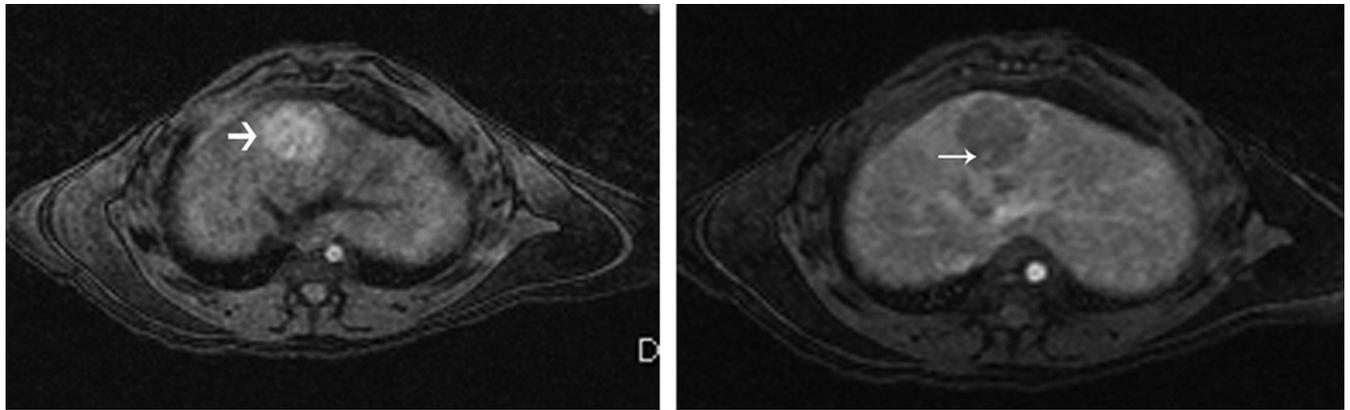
MR imaging appearance of treated HCC in a woodchuck model. (a) Precontrast T1-weighted image shows a spherical area of hyperintense signal at the site of ablation (arrow). (b) After intravenous gadolinium administration, the lesion shows minimal peripheral enhancement with subtle areas of nodularity (arrow).
